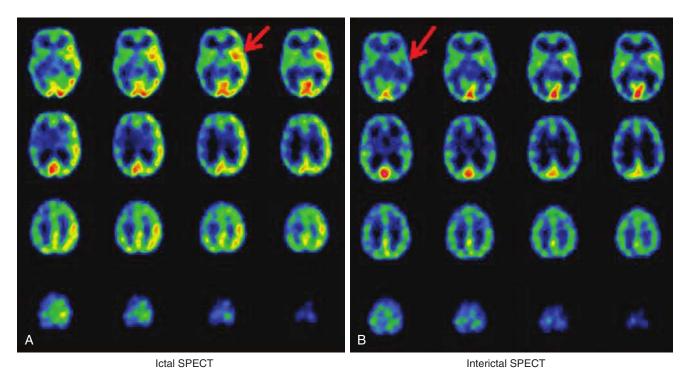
Ictal and interictal brain single-photon emission computed tomography (SPECT): An 11-year-old with intractable partial complex seizure and epileptogenic focus in the left temporal lobe. Ictal SPECT (A) demonstrates a focus of increased perfusion (*arrow*) in the left temporal lobe spreading to the left parietal lobe. Interictal SPECT (B) demonstrates a focus of decreased perfusion (*arrow*) in the left temporal lobe spreading to the left parietal lobe.
